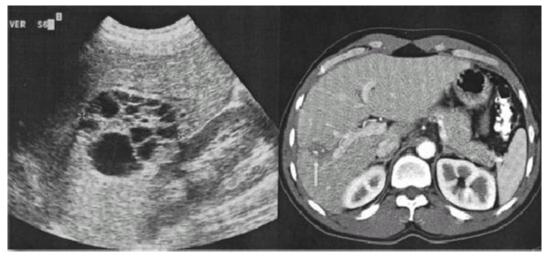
Ultrasound before percutaneous evacuation (PEVAC) of multivesicular cyst which had spontaneously ruptured into the biliary tree (left). Computed tomography scan 13 months after PEVAC shows (arrow) partially calcified cyst remnant (right).
